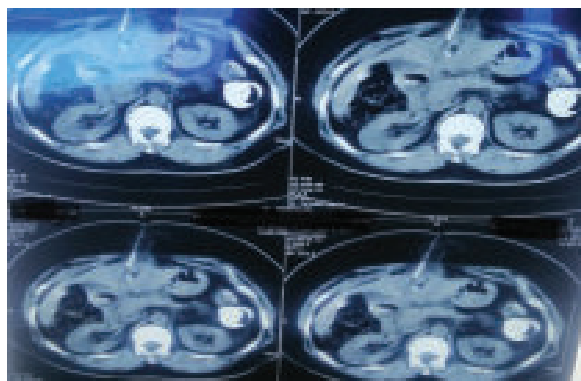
CT guided FNAC from abscess cavity
